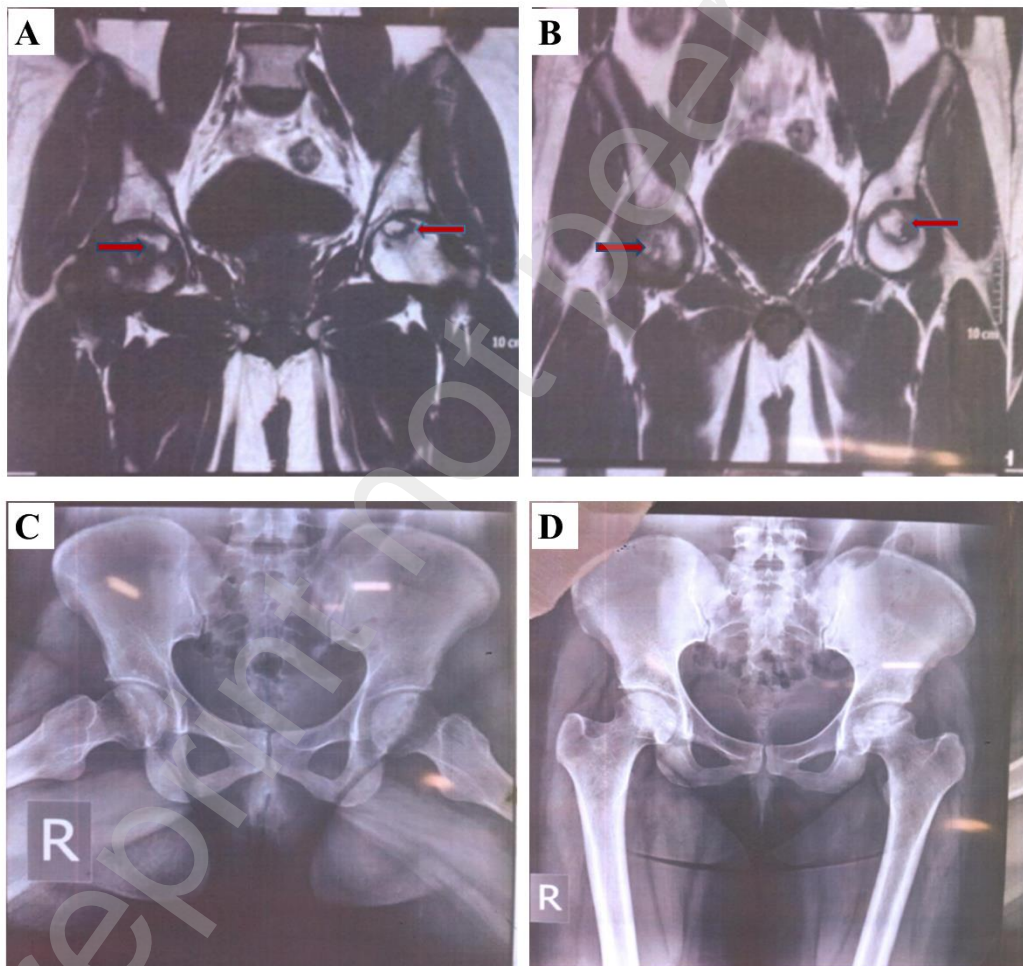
MRI (A and B) and anteroposterior radiograph (C and D) of the 27-year-old female patient confirming avascular necrosis of the femoral head of the bilateral hip (Ficat-Arlet-stage IIB).
